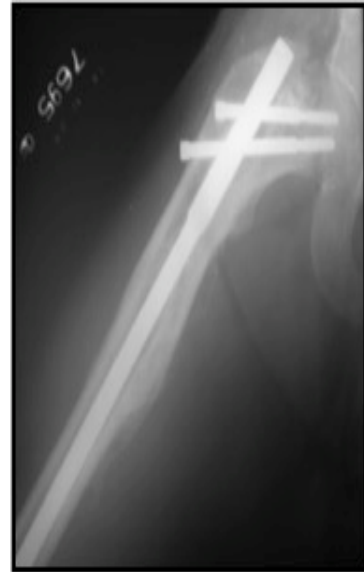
6 months follow up X-Ray
